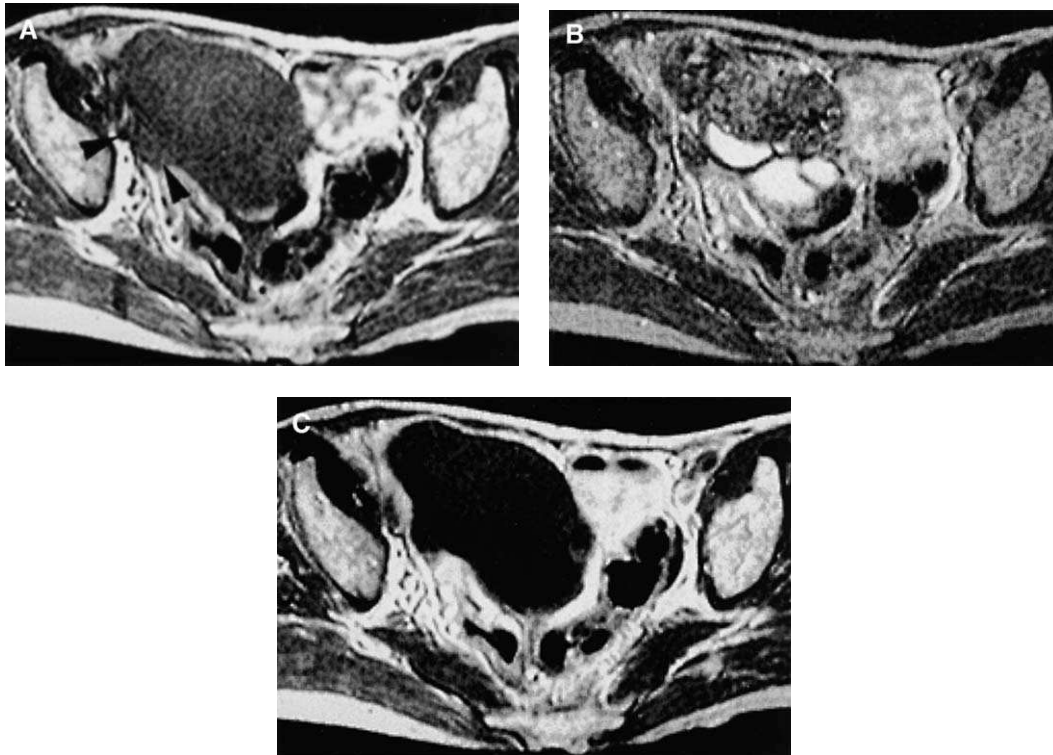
Torsed ovary with massive hemorrhagic infarction. (A) T1-weighted image shows a mass of intermediate signal associated with a beaked protuberance, which indicates a pedicle (arrowheads). (B) T2-weighted image shows distinct low intensity, which indicates necrosis. (C) Postcontrast image reveals complete absence of any enhancement.
